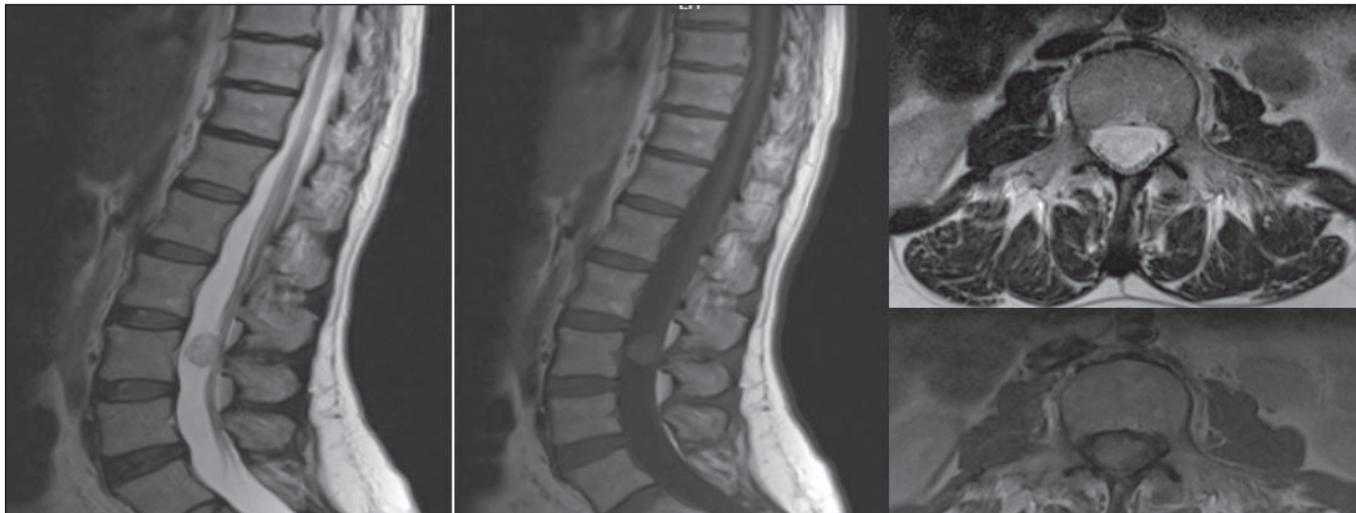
T1, T2 sagittal, and T2 axial MRI showing an 18 ×16 × 12 mm intradural mass homogeneously Gd-enhanced at the level of L3.
